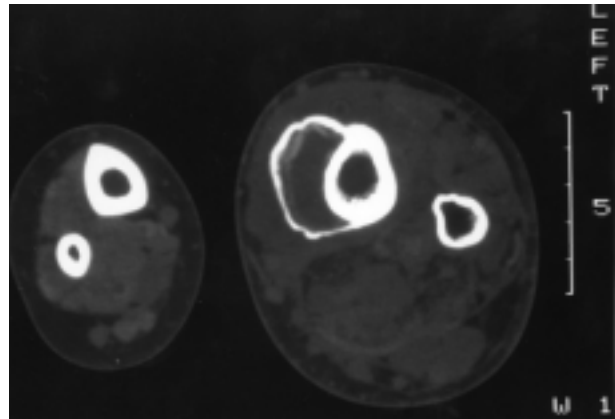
CT-scan of the lower legs shows a hypoplastic right and a hypertrophic left lower leg, and elevation of the periosteum of the left tibia. Note the beginning ossification in the periphery of the subperiosteal hematoma.
